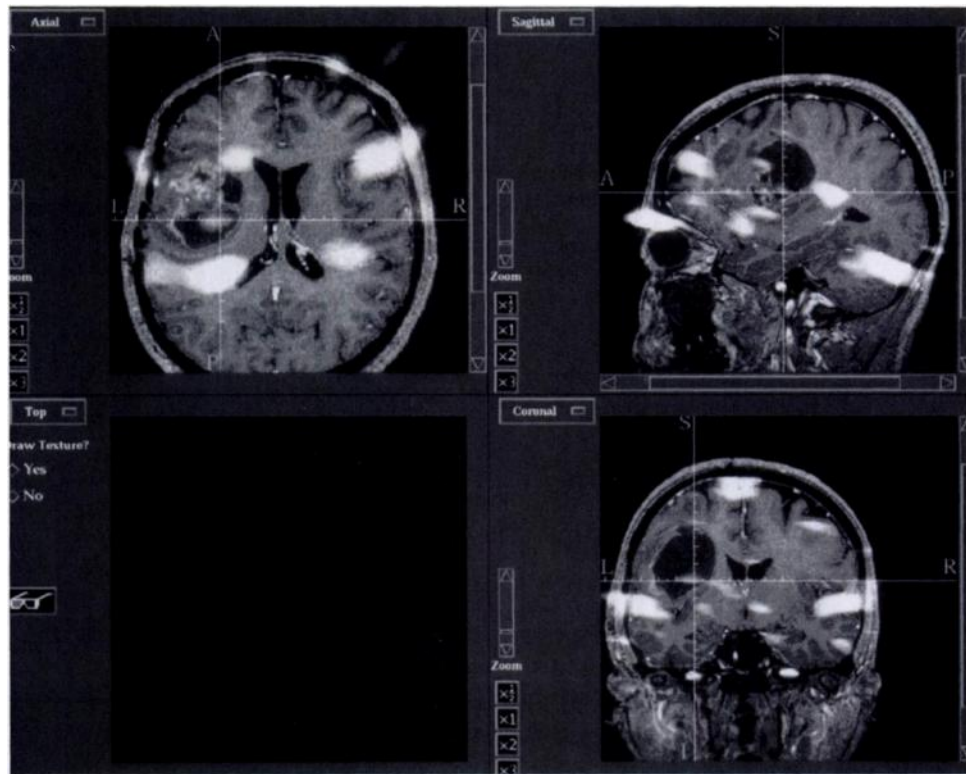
Images obtained with a multimodality image-guided neurosurgery system show data from a functional positron emission tomographic activation study superimposed on anatomic MR images used during lesion resection.
